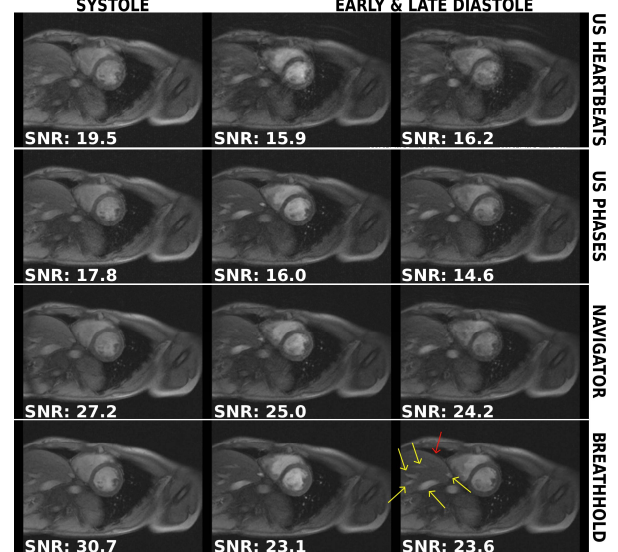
Systole and diastole short axis images were acquired using ultrasound gating, navigator gating and breathhold. The gating window was dynamically adjusted to $p_{amp} = \pm 20\%$. Liver vessels and the border of the liver are highlighted (yellow and red arrows, respectively).
